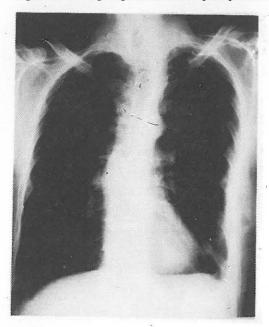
Roentgenogram on the ninth postoperative day
